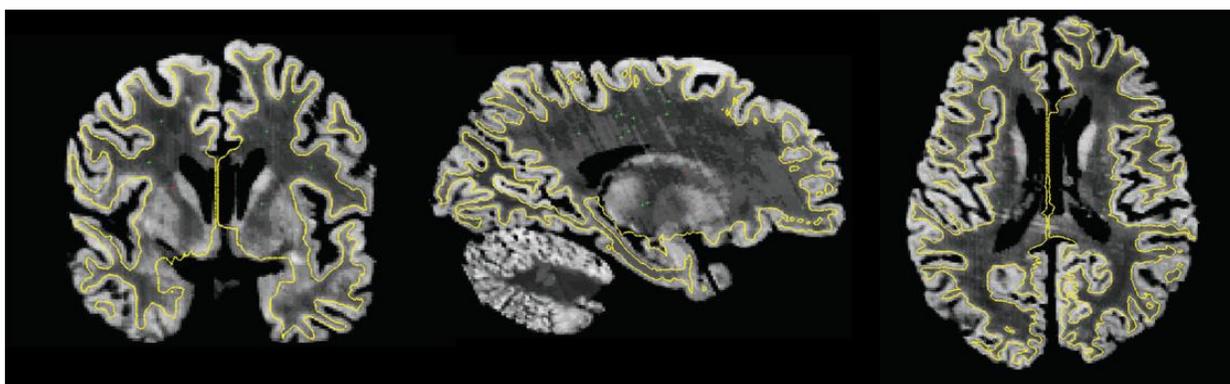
Image of a reconstructed MRI dataset from Fischl et al., (2008). The yellow line represents the grey matter/white matter surface, with cortical grey matter external to this line. Coronal, sagittal and axial views are presented from left to right.
